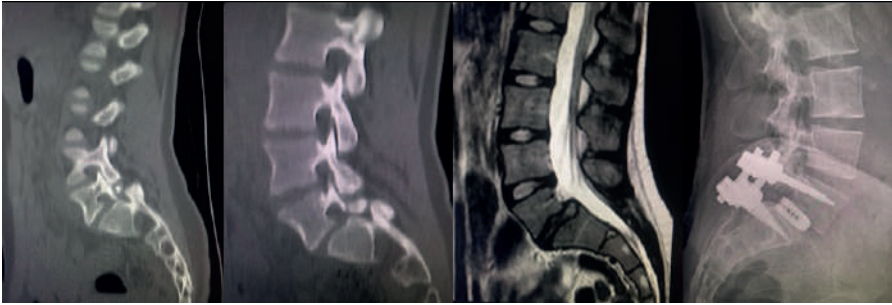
Preoperative CT/MRI and postoperative radiograph in isthmic spondylolisthesis. Preoperative sagittal CT and MRI images of a 22-year-old female patient demonstrating L5–S1 isthmic spondylolisthesis with bilateral pars interarticularis defects. The postoperative lateral radiograph shows L5–S1 posterolateral stabilization and posterior lumbar interbody fusion (PLIF) instrumentation, confirming appropriate implant placement and restoration of lumbosacral alignment.
